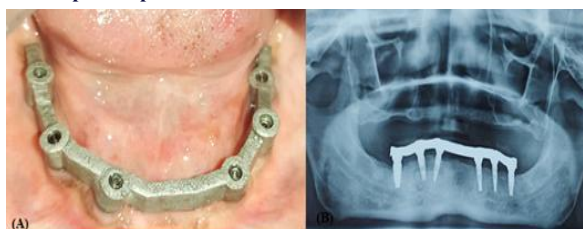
CAD-CAM milled titanium framework (A) Clinical evaluation (B) Radiographic verification.
